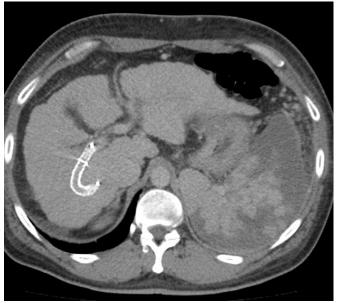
Multislice spiral computed tomography of the abdominal organs with intravenous contrast. Portosystemic shunt in a typical location. Postoperative abnormalities in the spleen
